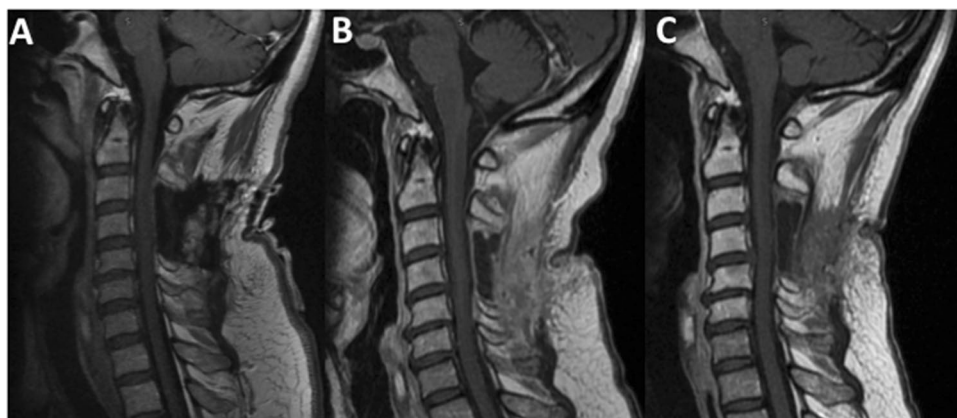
T1-weighted MRI of the cervical spine with contrast at initial (a), 3 months (b) and 6 months (c) postoperatively showing no residual tumor
